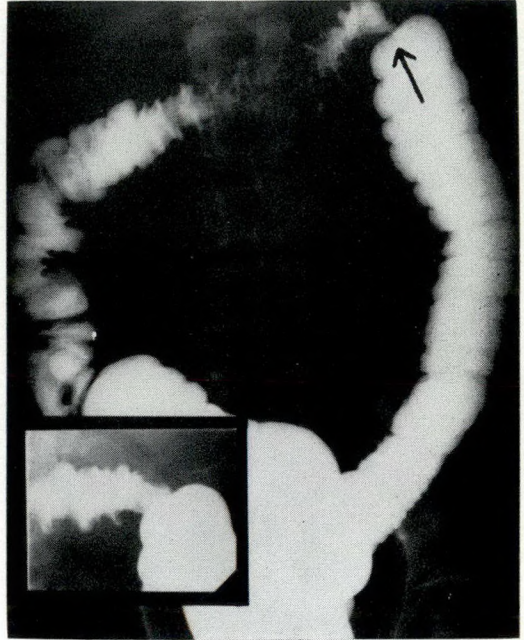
Case 3: The large roentgenogram and the spot film in the insert demonstrate incomplete obstruction at the splenic flexure.
